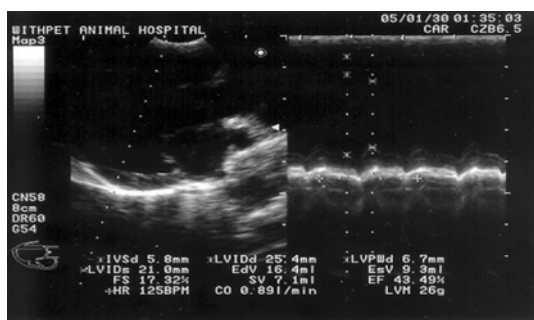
Ultrasonographic finding on 10 days after operation.
